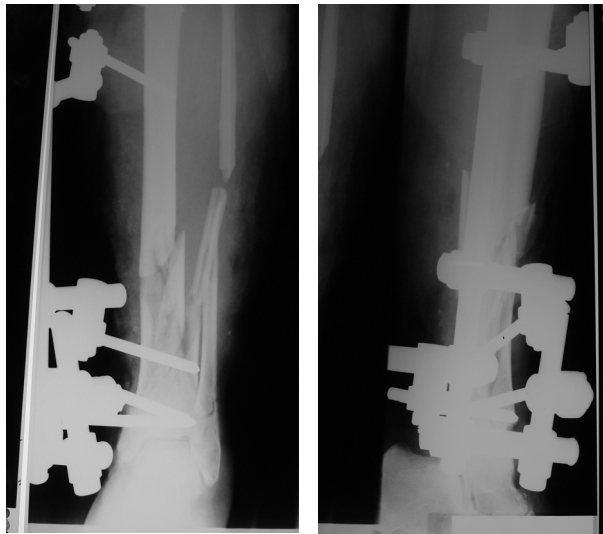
On the X-ray recordings of open tibial shaft fracture of the right lower leg, a good reposition of broken fragments of the right tibia can be seen, which are stabilized by external skeletal fixation
